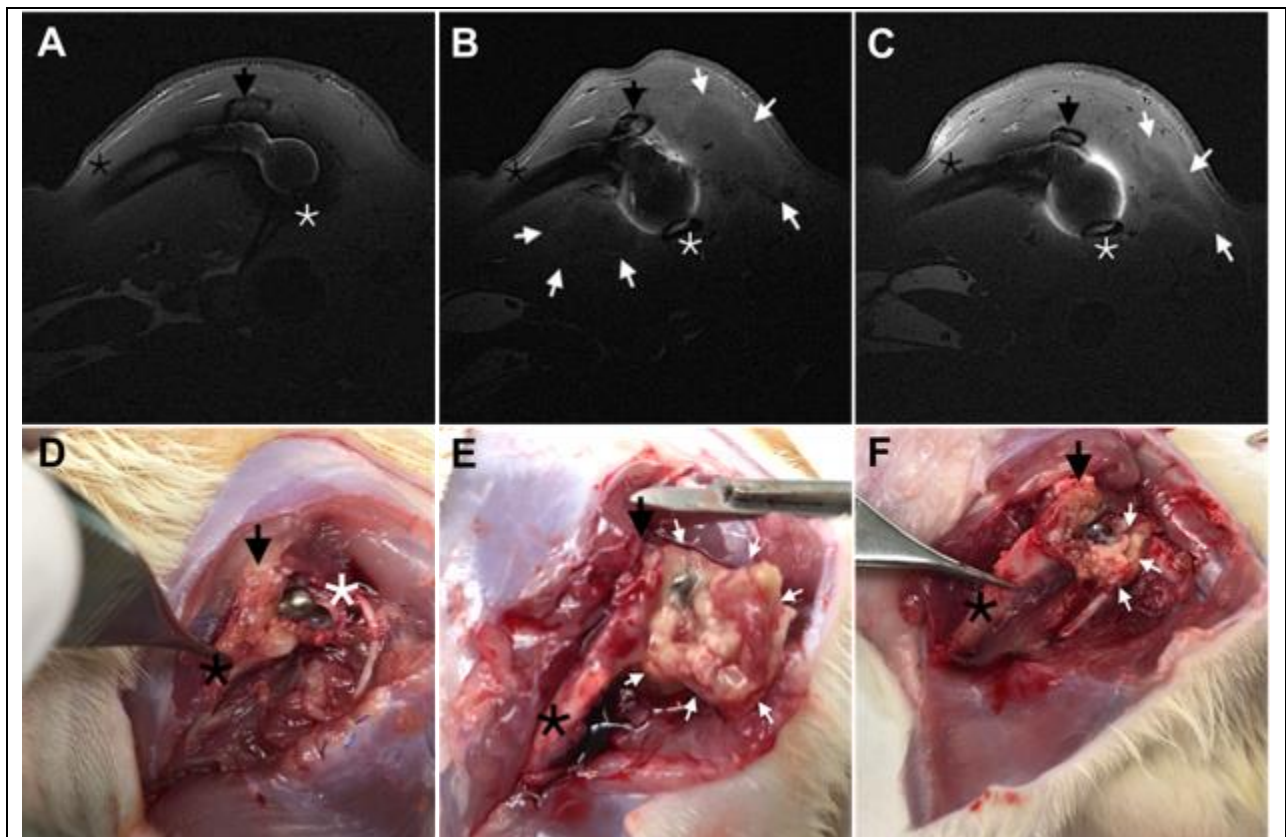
Representative sections of left hip MRI for A) a non-infected surgical control (n=2), B) PA14-*lux*-PJI (n=3) demonstrating periprosthetic abscess (white arrows) and C) *AflgK-lux*-PJI (n=3) with a relatively smaller abscess (white arrows). The MRI images demonstrated stable implants in position with the stem inside the femoral canal (black asterisk) and the head articulating with the acetabulum (white asterisk). Greater Trochanter (black arrow).
